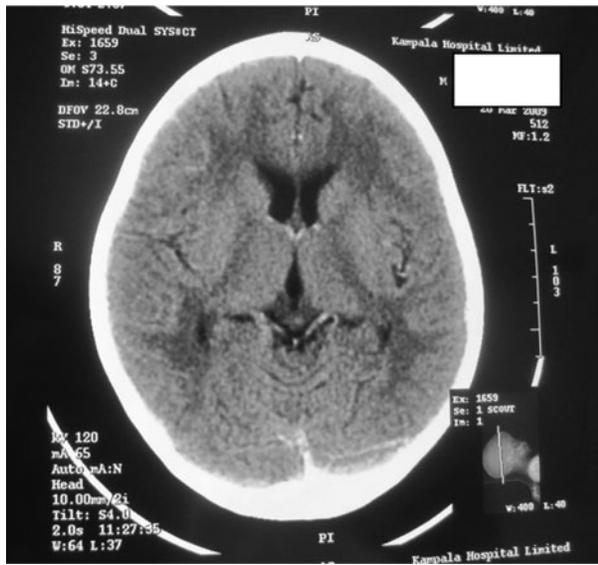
Brain computerized tomography (CT) scan of the child at admission.
